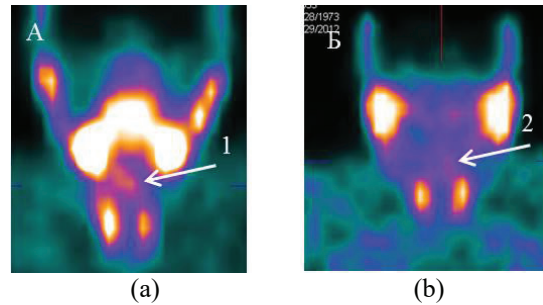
Results of SPECT with ^{99m}Tc -MIBI in 2 patients with chronic hyperplastic laryngitis, false-positive results: (a) increased accumulation of the radiopharmaceutical is visualized in the projection of the right larynx (1); (b) a site of low-intensity accumulation of the radiopharmaceutical with fuzzy contours in the projection of the left larynx is visualized (2)
